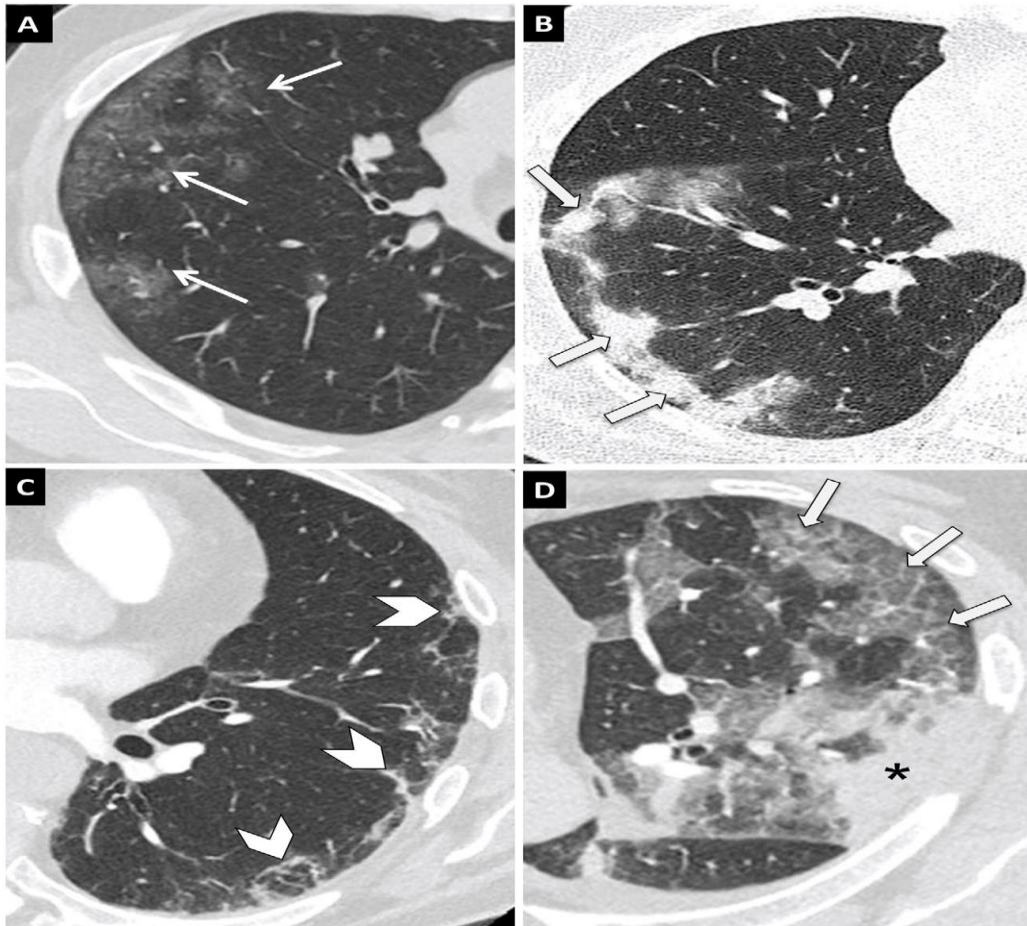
Typical findings in COVID-19 pneumonia on computed tomography (CT). Axial chest CT images with 1-mm slice [134].
